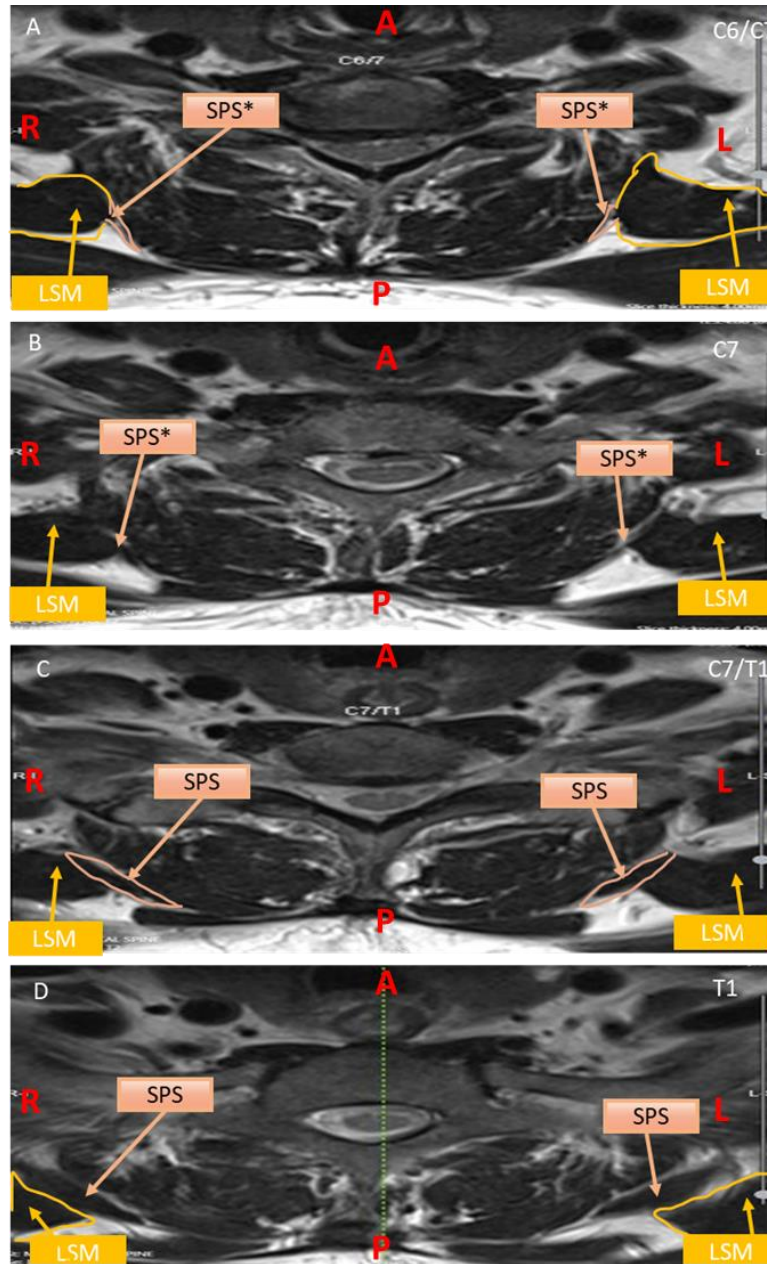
The axial cervical MRI scans with serratus posterior superior attachments of the levator scapulae muscle (A to D = superior to inferior). The MRI scans were obtained from a 62-year-old male patient (p# 17), with bilateral accessory attachments to the serratus posterior superior. Key: C- cervical vertebrae, LSM- levator scapulae muscle, SPS- serratus posterior superior, SPS*- attachment to the serratus posterior superior, T- thoracic vertebrae. Orientation in red: A- anterior, L- left, P- posterior, R- right.
